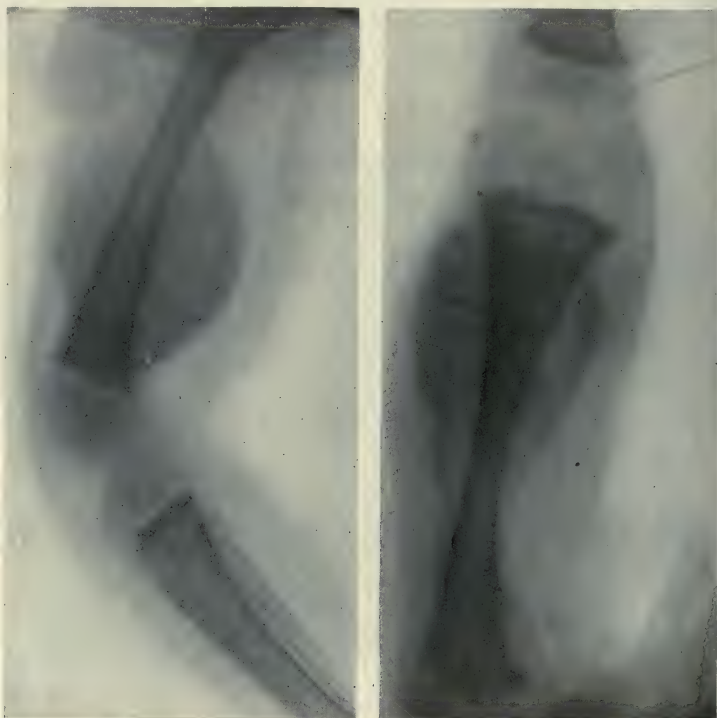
Extreme case of scorbutus. The extensive hemorrhagic exudate beneath the periosteum in this case is especially well shown by the x-ray.
